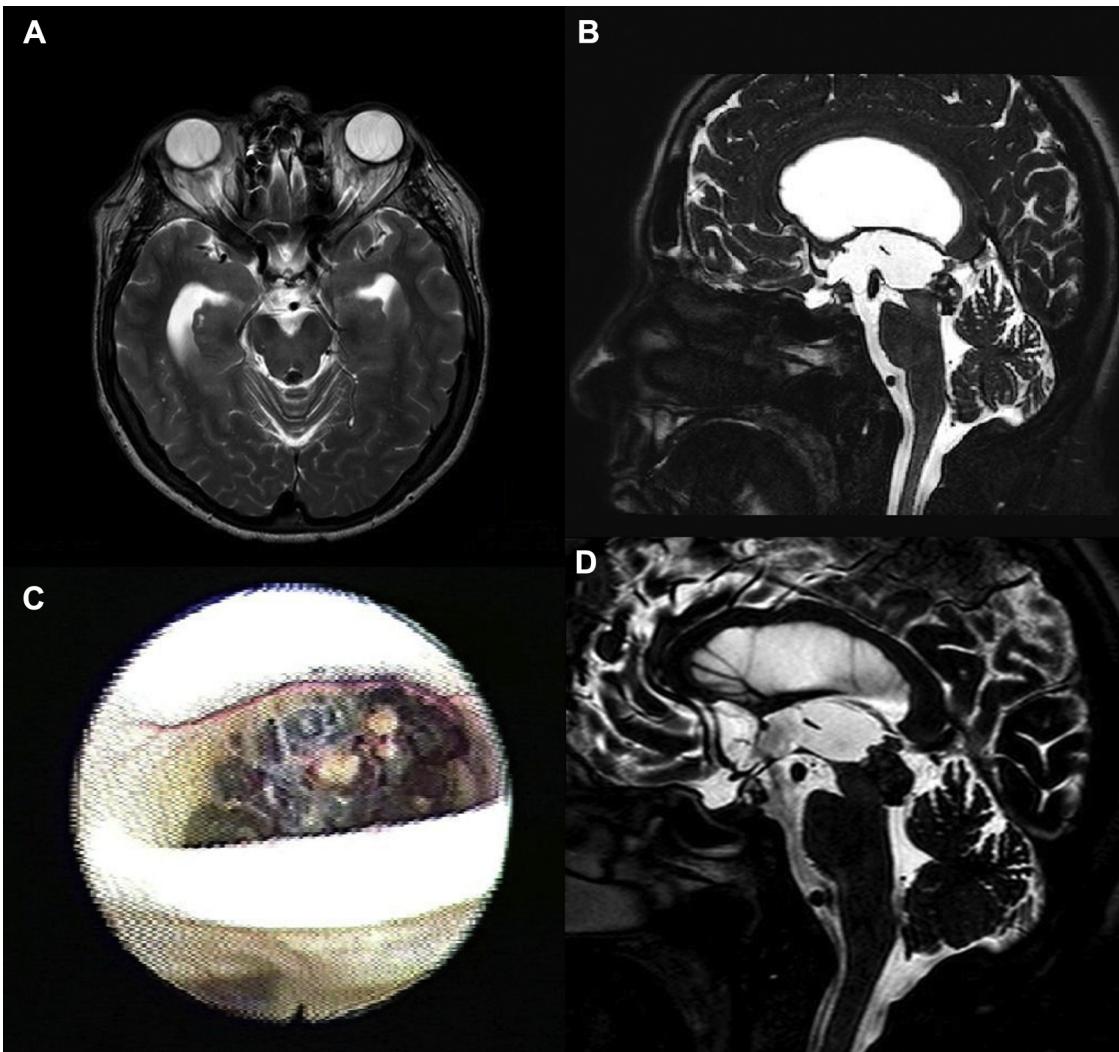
Preoperative (A) axial and (B) sagittal T2-weighted magnetic resonance imaging showing the cavernous angioma located in the lumen of the cerebral aqueduct. (C) Intraoperative
